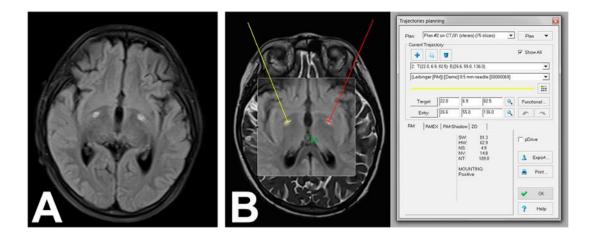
Image fusion between preoperative and post-bilateral pallidotomy brain MRI in a patient with refractory ED secondary to PKAN. The almost exact correspondence between the presurgical planning and the postoperative result is shown.
